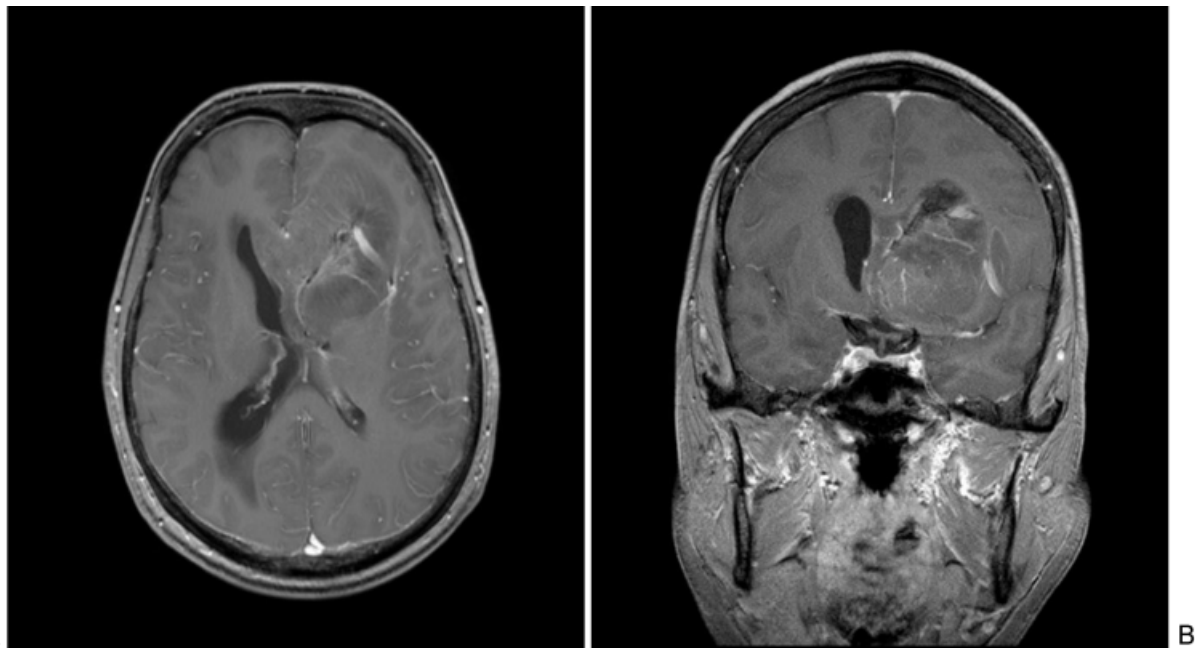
(A) Axial and (B) coronal T1-weighted magnetic resonance images enhanced with gadopentetate dimeglumine demonstrating an intracranial tumor in the left frontal lobe with spread to the opposite hemisphere crossing the corpus callosum and still including radiologic signs for a venous malformation.
